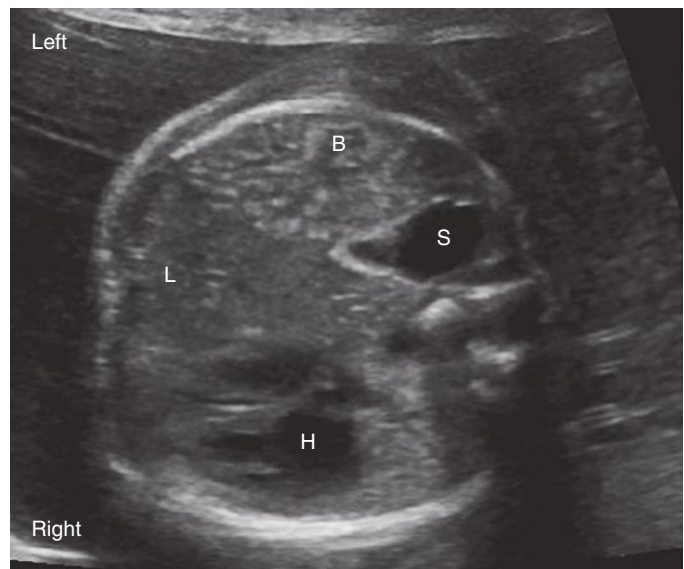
Axial sonographic image through the chest in fetus with left congenital diaphragmatic hernia. Fluid-filled stomach (S), bowel (B) and portion of the liver (L) are shown on the left, with displacement of the heart (H) toward the right. It is estimated that 1% to 10% of fetuses with congenital diaphragmatic hernia have Fryns syndrome.
